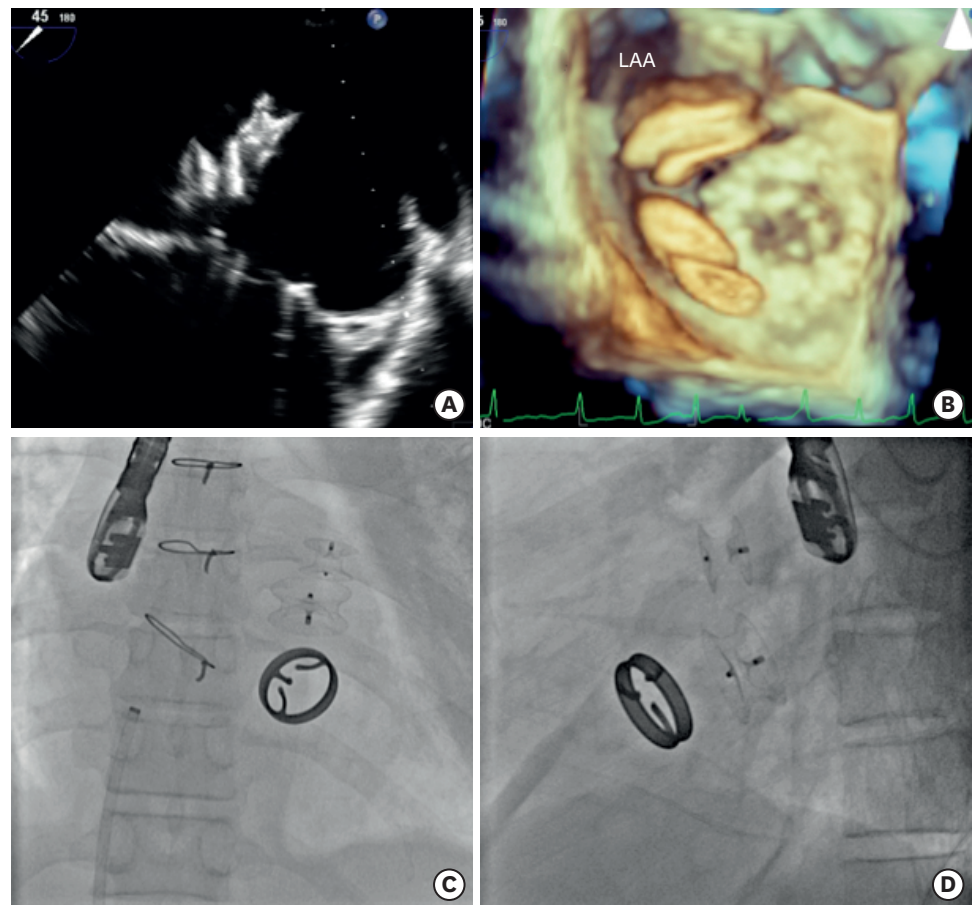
Embolization of the 2 devices was noted few minutes later on transesophageal echocardiogram (A) and 3-dimensional view (B) as well as fluoroscopy (C, D) where they appeared as floating butterflies (Movie 3) due to the impact of the regurgitant jet on the devices in left atrium. LAA: left atrial appendage.
